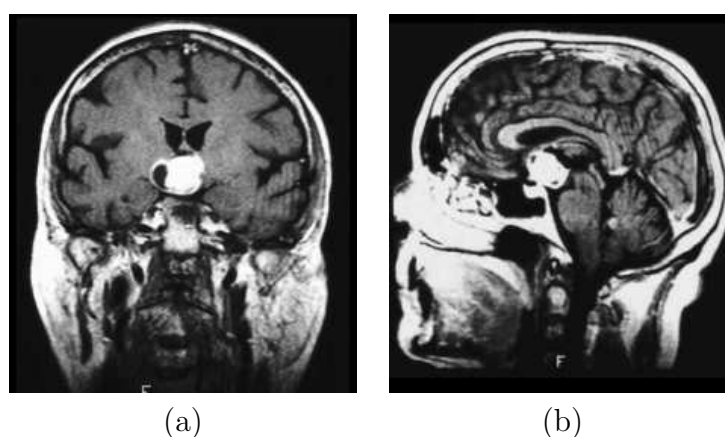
Craniopharyngioma. a) Coronal contrast enhanced T1-weighted image showing an enhanced solid portion of the tumor together with a hypodense cystic component on the right side of the tumor. b) Sagittal view of the same tumor [Wen et al., 2001].
